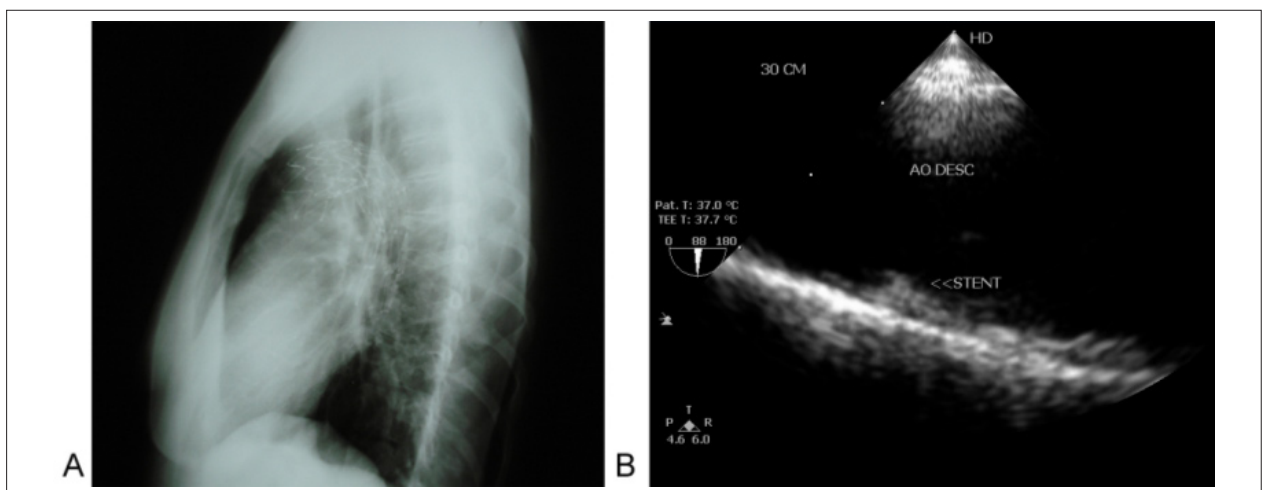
A. Chest x-ray showing the positioning and expansion of the endoprosthesis. B. Transesophageal echocardiogram showing good coaptation of the endoprosthesis and elimination of the ductus arteriosus.
